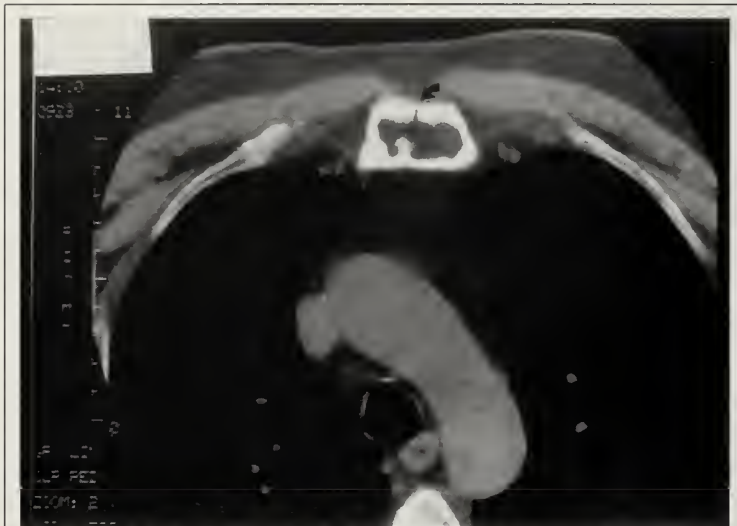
CT of sternum revealed empty marrow without soft tissue mass on previous puncture site (arrow).
